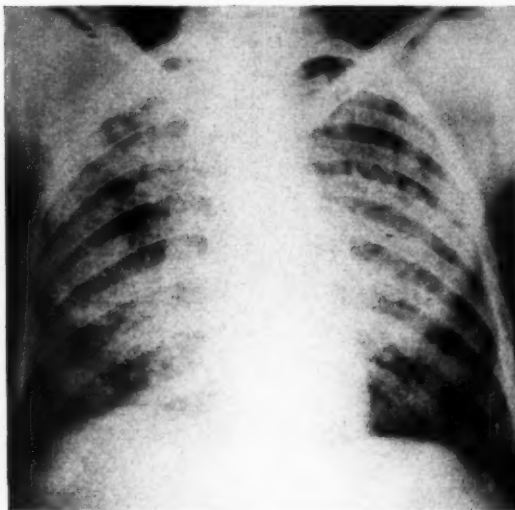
Roentgenogram of the chest of a man of thirty-two years of age. This shows miliary tuberculosis, involving both lungs. There is an old lesion with cavity formation in the right upper lobe.
